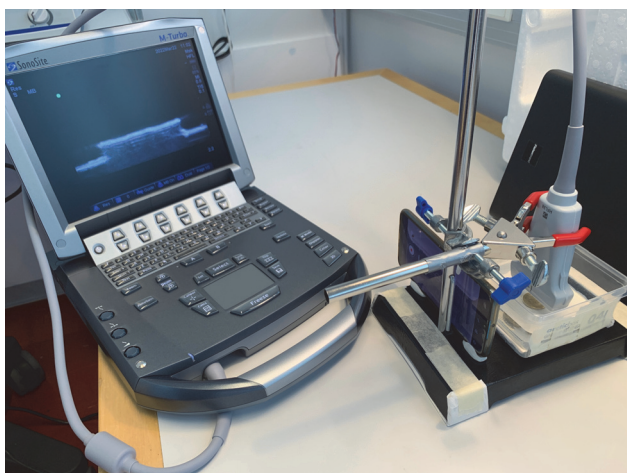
Photographic overview of the disintegration setup. An ultrasound probe was clamped facing downward towards a nickel-brass 1-SHP reflector inside a water-filled container. A cellphone positioned on the clamp stand was used for capturing continuous video footage.
